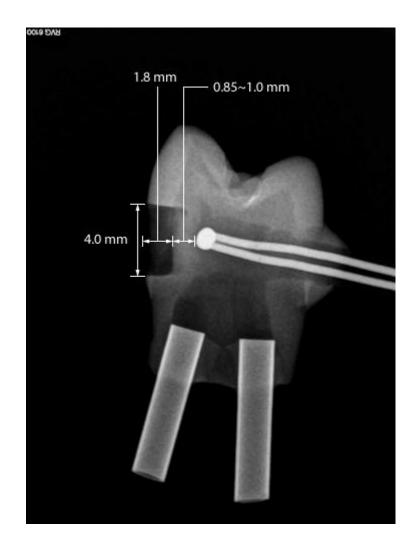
X-ray of the prepared premolar with a thermocouple and a metal tube.
